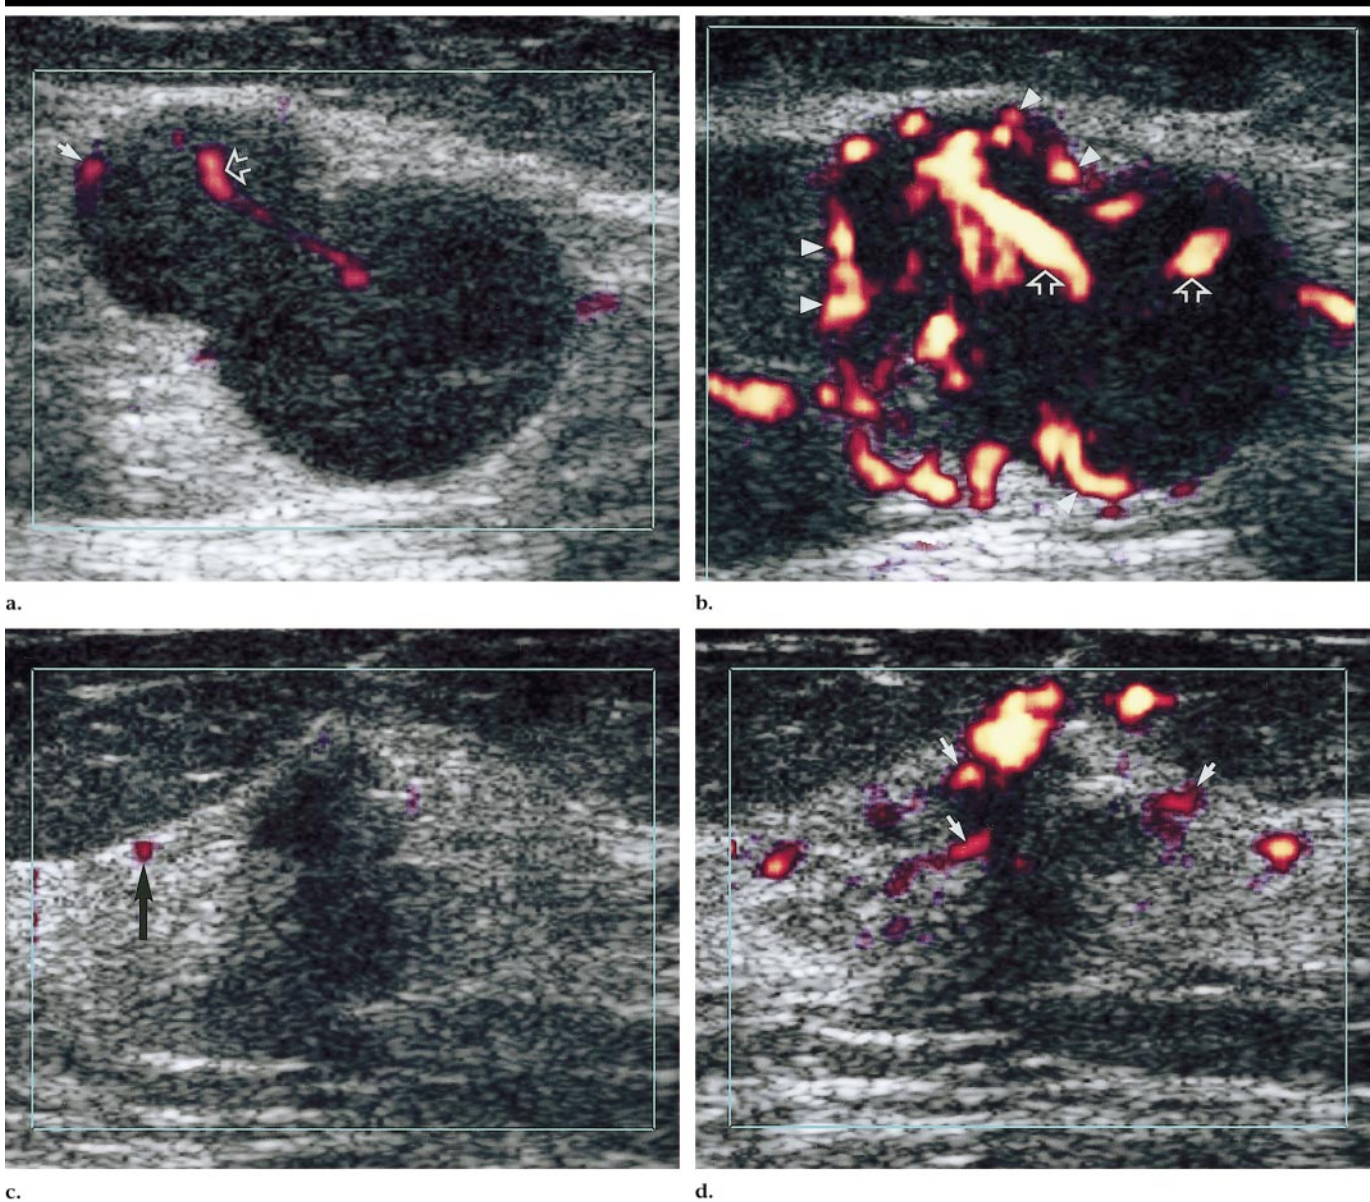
(a) Precontrast radial color power Doppler US image of a malignant axillary node shows central (open arrow) and peripheral (solid arrow) vessels. (b) Postcontrast radial color power Doppler US image of the same lesion as in a shows a florid increase in central (arrows) and peripheral (arrowheads) vessels. (c) Precontrast radial color power Doppler US of the corresponding breast cancer in the same patient as in a shows a solitary tiny vessel (arrow) outside of the lesion. (d) Postcontrast radial color power Doppler US image of the same lesion as in c shows a moderate increase in the number of peripheral vessels (arrows). This increase is markedly lower than the increase in peripheral vessel number in the axillary node seen in b.
